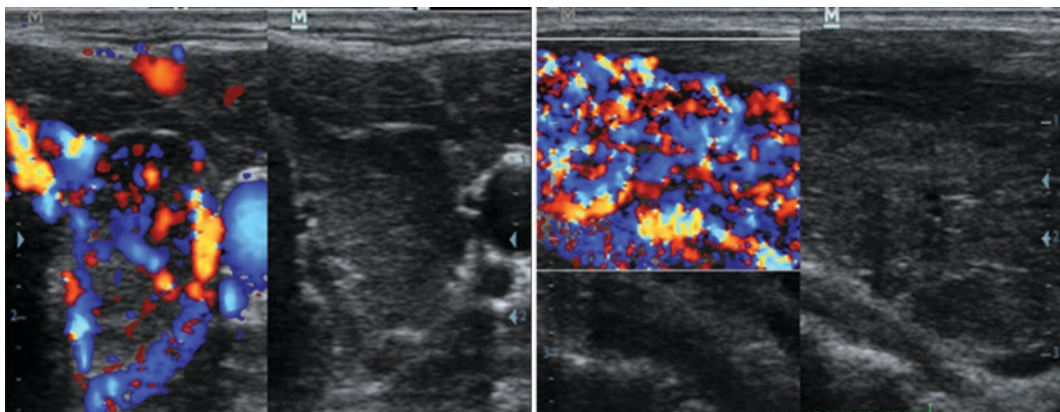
Ultrasound pictures of Graves' disease: the so called thyroid inferno is seen. The main echotexture is mostly decreased, inhomogeneous with extremely increased diffuse hypervascularity on color Doppler
